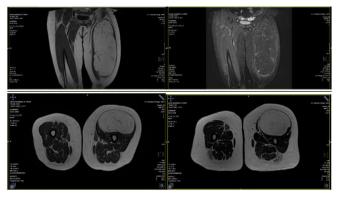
Different MRI pictures of giant lipoma of left thigh.
